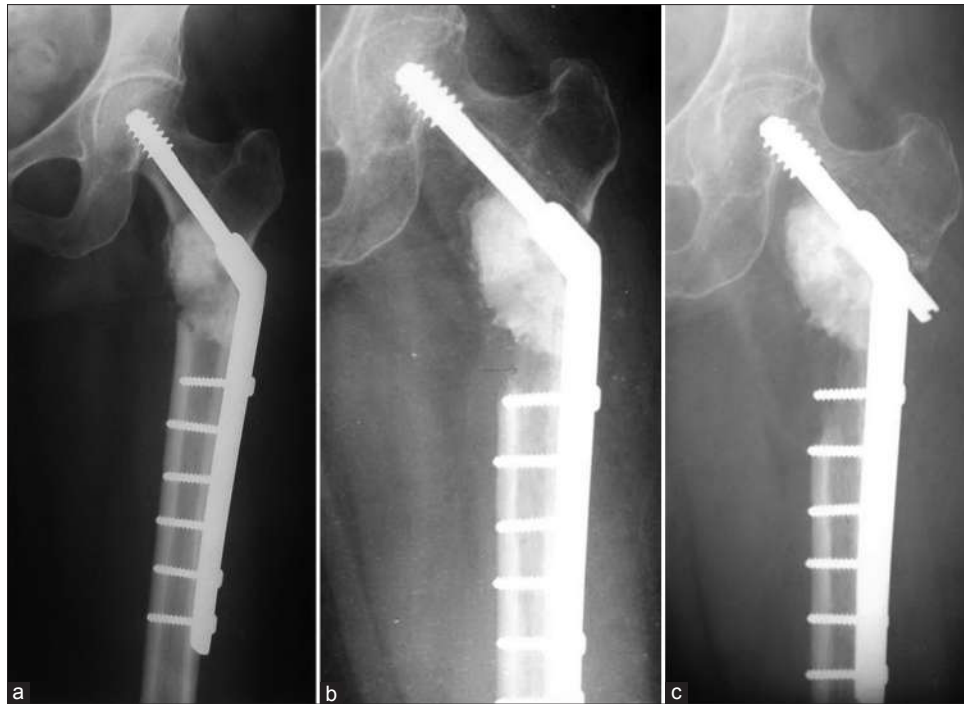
(a) Postoperative X-ray after intralesional curetting and cementing of a metastatic lesion from breast cancer (b) Local recurrence is seen within a year despite postoperative radiotherapy (c) Progressive disease which required resection. In patients with long expected survival, primary resection may obviate need for more surgery in future
